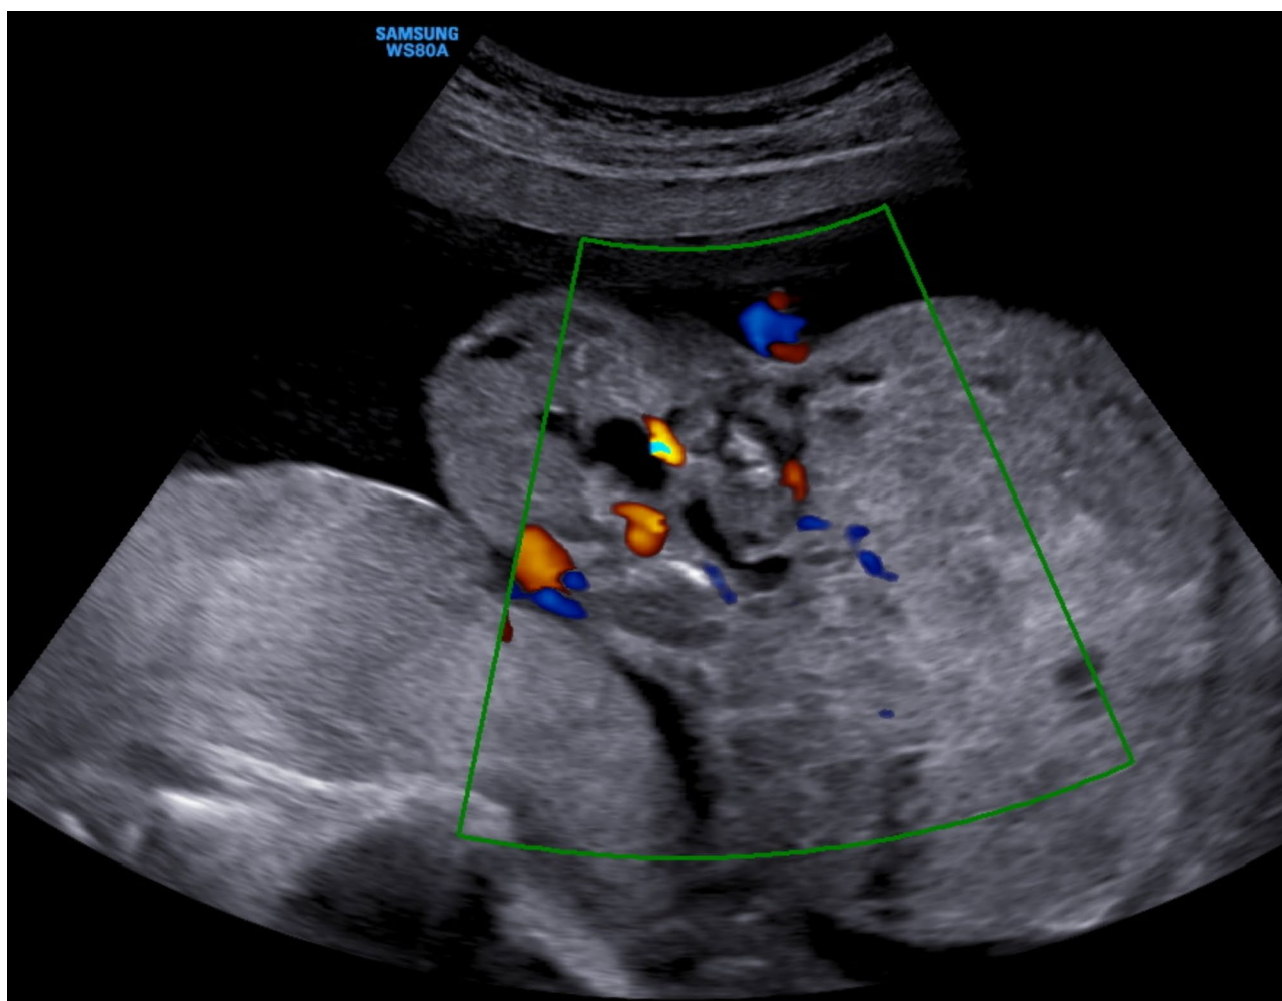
Doppler imaging of the tumor vascularization (case 1, terminated pregnancy)
